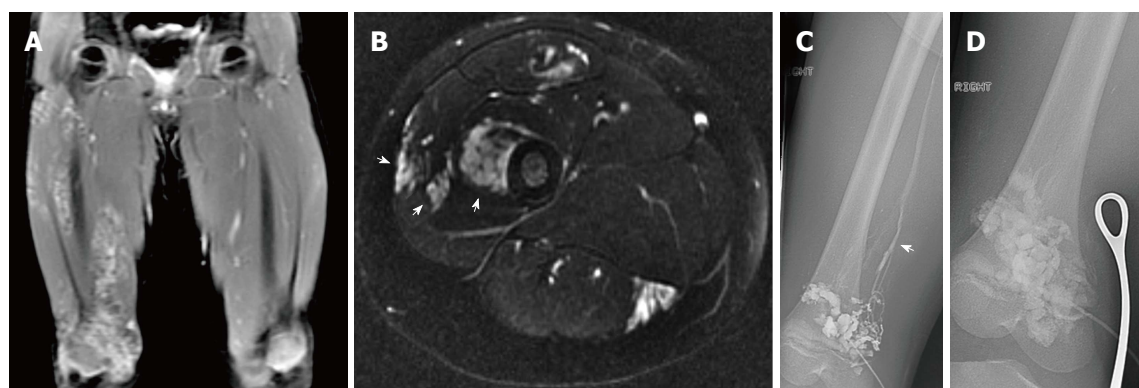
Infiltrative extratruncular low flow vascular malformation of the right leg. Coronal (A) and axial (B) T2-weighted magnetic resonance images demonstrate a high signal intensity infiltrative lesion (arrows). Venography (C) demonstrates filling of the malformation with outflow communication to the femoral vein (arrow). Sclerosis was subsequently performed utilizing 3% STS opacified with contrast (D) with compression of the outflow vein using metal forceps.
